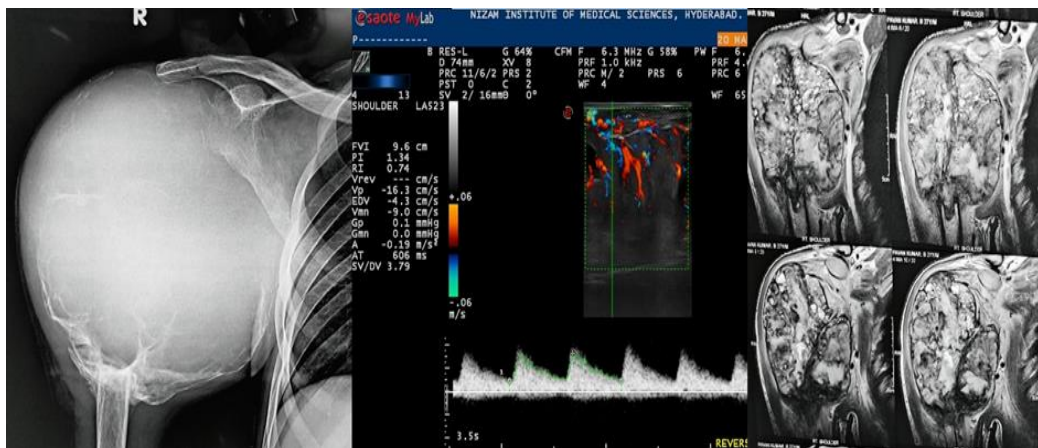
23/M Grossly expansile lytic lesion with imperceptible wall and no internal trabeculae. Increased vascularity seen on USG and Fluid- Fluid levels are well appreciated on T2W MRI
